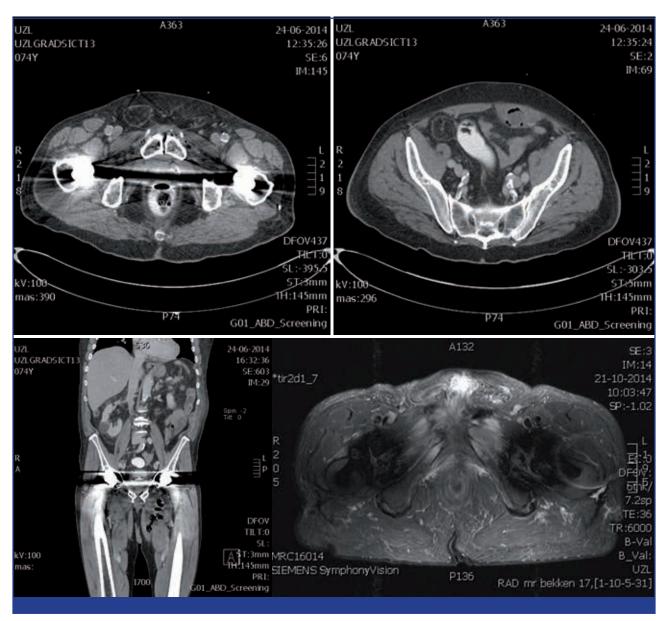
Patient 1: preoperative CT images of the pubic symphysis with free air (top left) collection in the m. rectus abdominis (top right), and adductor compartments (bottom left), MRI TIR image showing bone oedema of both pubic arches (bottom right).
